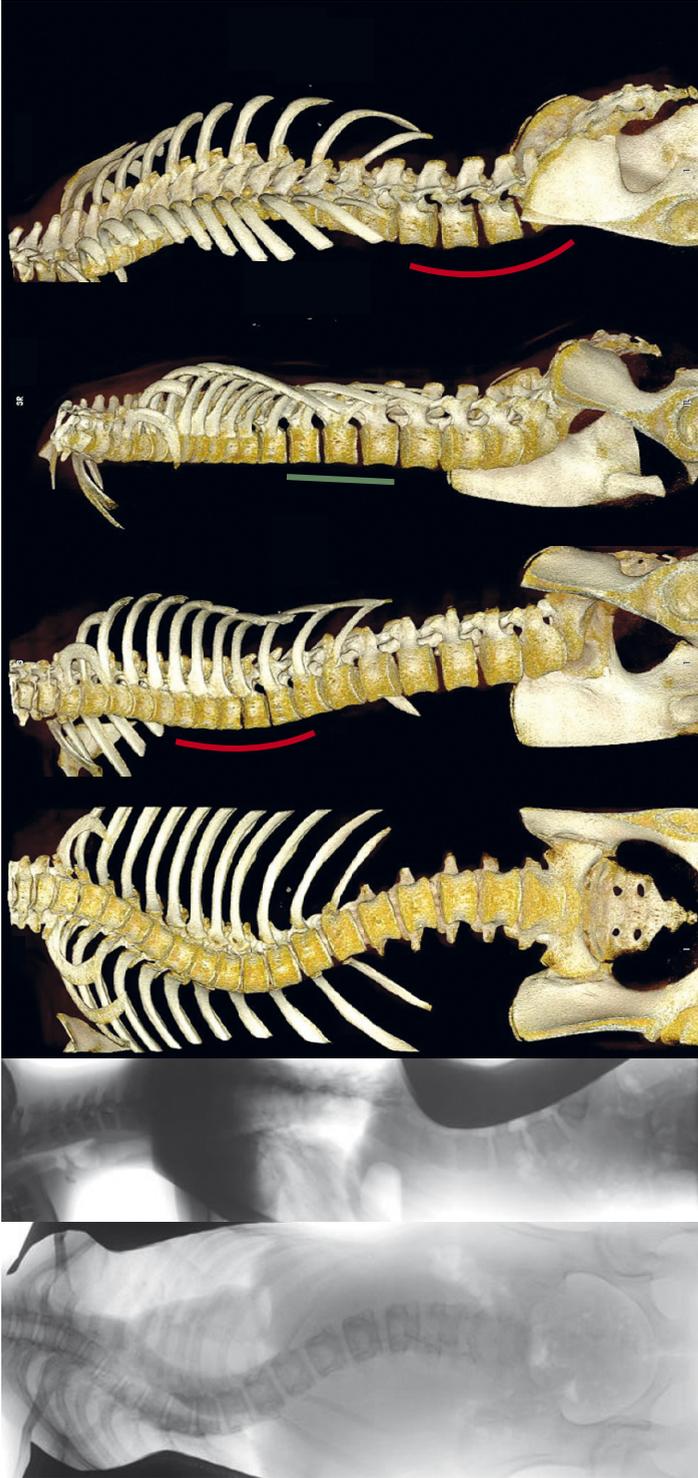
Antero-posterior and lateral radiographs, and computed tomography reconstructions (OsiriX 64-bit; OsiriX Foundation, Los Angeles, CA, USA) are shown from an anterior and anterolateral view. In this representative 15-year-old patient with adolescent idiopathic scoliosis with a typical thoracic curve pattern, anterior overgrowth cannot be observed on the lateral radiography. The rotated lordoses of both thoracic and the (thoraco)lumbar curvatures, with a clearly longer anterior spinal column than posterior elements, are shown in *red*, and the straight junctional segment in-between in *green* from a true lateral view for these regions.
